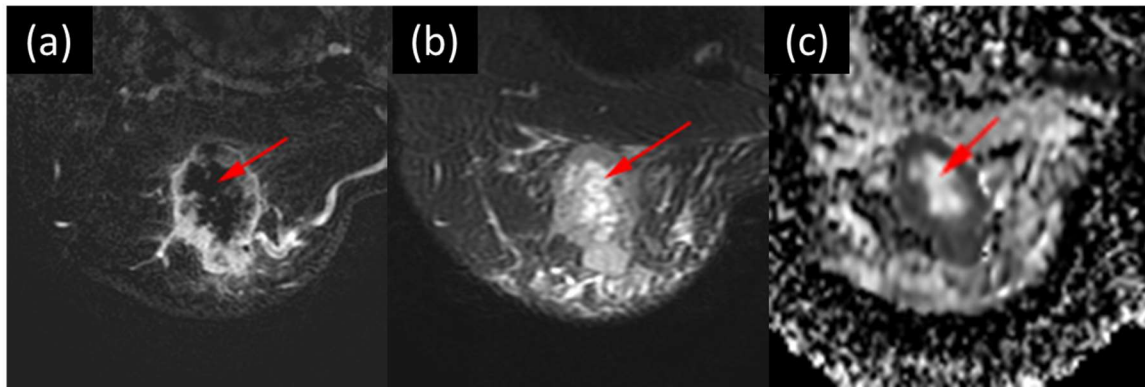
Necrotic index carcinoma with a pathological complete response after neoadjuvant systemic therapy in a 46-year-old woman with TNBC of the right breast. The volume of necrotic material was 10 cm³, and the percent of the total tumor volume occupied by necrosis was 17%. (a) Axial fat-suppressed early-phase dynamic contrast-enhanced image shows central non-enhancing area representing necrosis (arrow). (b) Axial fat-suppressed T2-weighted image shows necrosis as central area of high signal intensity (arrow). (c) Axial apparent diffusion coefficient map shows shine-through corresponding to central area of necrosis (arrow).
